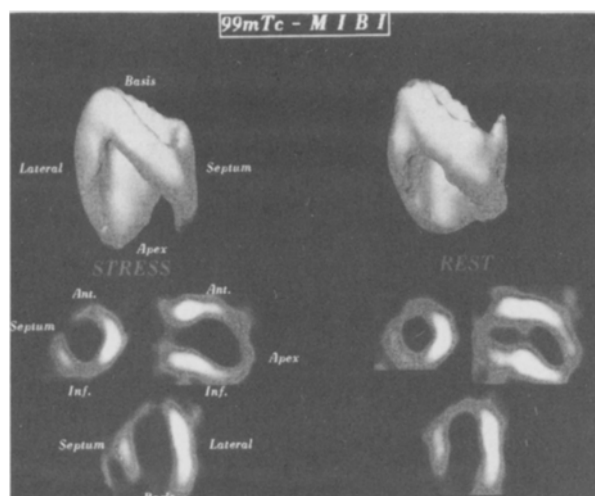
Myocardial scintigraphy: pseudo-3D reconstruction of the well perfused myocardium (under stress) and in rest (upper row, seen from posterior): The large defect includes the apex of the left ventricle and represents afunctional (not absent!) myocardium; this defect decreases with rest, indicating a rim of stress-induced myocardial ischaemia. The slices, displayed along short left ventricle axis, sagittal and long axis (bottom), represent cutouts from the standard presentation of a multitude of slices.
